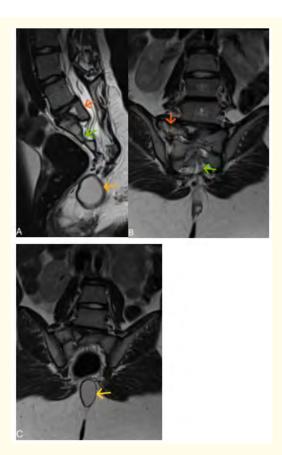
(A) Sagittal T2-weighted image showing a right hemivertebra at L5 (orange arrow), partial sacrococcygeal agenesis (green arrow), and neuroenteric cystic (yellow arrow). (B) Coronal T2-weighted image demonstrating partial sacrococcygeal agenesis (green arrow) and right hemivertebra at L5 (orange arrow). (C) Coronal T2-weighted image showing a sacrococcygeal neurenteric cyst, exhibiting hyperintense signal on T2, extending to the skin without pelvic involvement (Yellow arrow).
